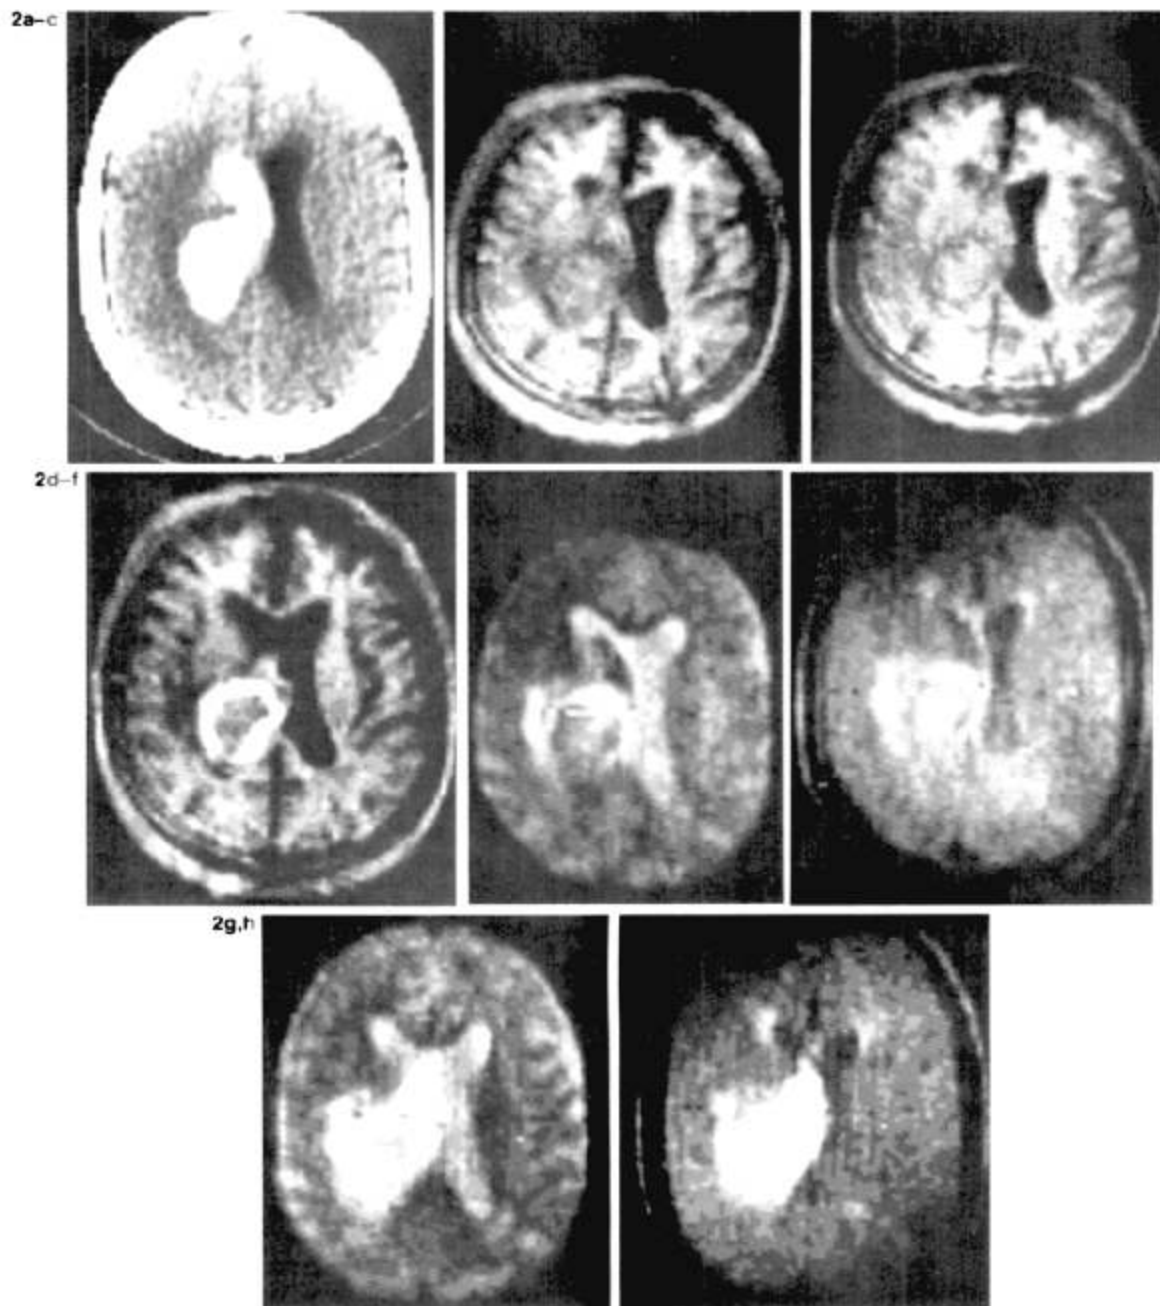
Patient 11. Noncontrast CT (a) and inversion recovery ($IR_{1,500,400}$) (b) and $IR_{1,500,600}$ (c) images of a 45-year-old man with spontaneous intracerebral hemorrhage 2 days after the onset of symptoms. Repeat $IR_{1,500,400}$ image at 9 days (d) Spin-echo ($SE_{2,000,100}$) and $SE_{500,100}$ images at 2 days (e and f) and at 9 days (g and h).
